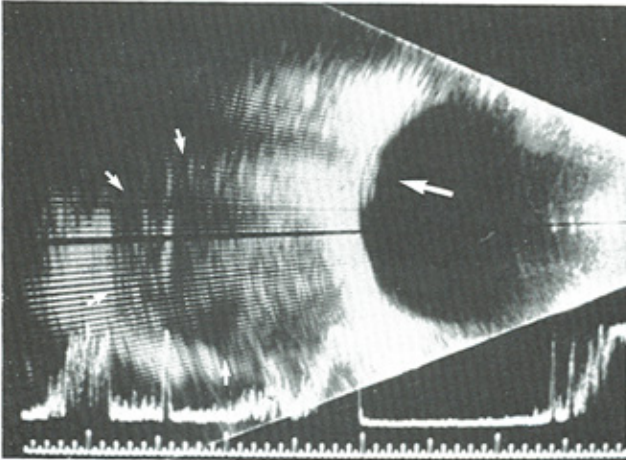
Orbital ultrasound showing the retrobulbar tumor (small arrows) with heterogeneous internal echoes. Elevation of the optic disc was also noted (large arrow). (Courtesy of Dr. Peter Lou.)
